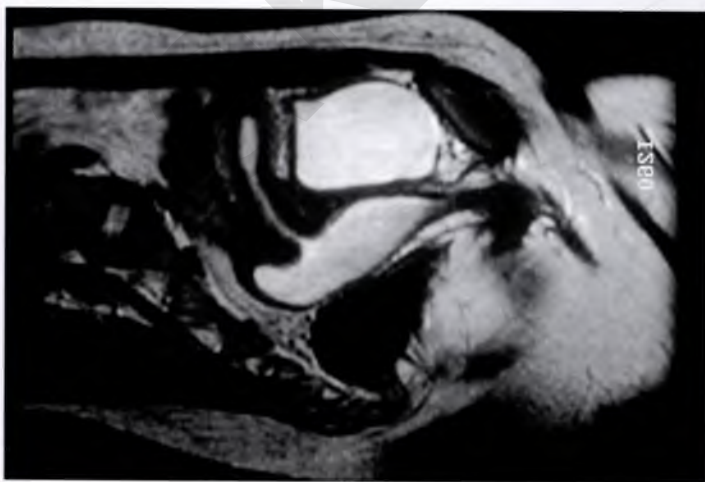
Magnetic resonance image of a patient with a large transverse vaginal septum. The hematocolpos is white. The vagina communicates with the uterus, and a hematometrium is evident.
